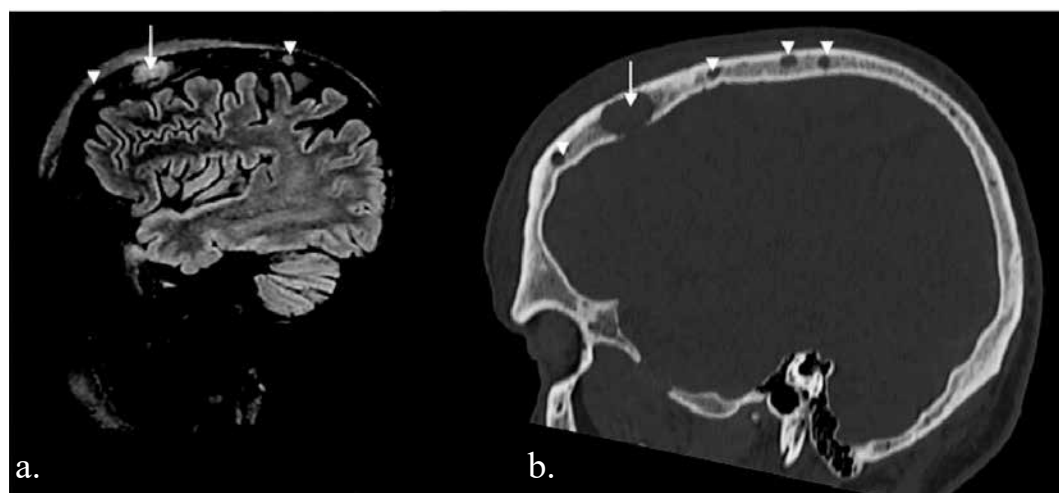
Osteolytic changes of the skull cap - single dominant in the left frontal bone with destruction of the inner and outer plates (white arrows) and smaller changes in the vicinity (arrowheads). 1a. MRI T2 FLAIR images in the sagittal plane 1b. sagittal CT reconstruction in the bone window.
